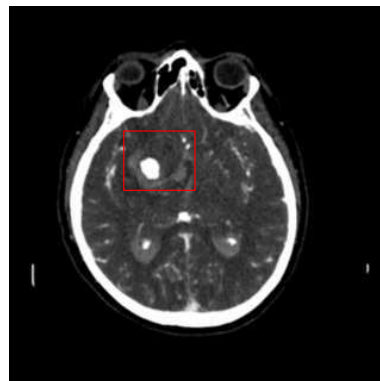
An example of 2D CTA slice with cerebral aneurysm.
